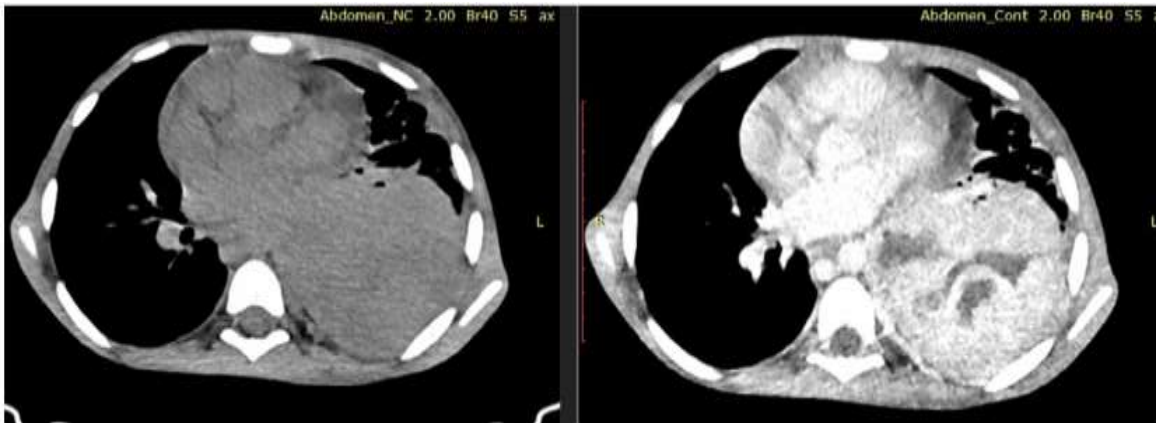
Chest CT Showing Recurrent Heterogeneously Contrast Intrathoracic Enhancing Mass
